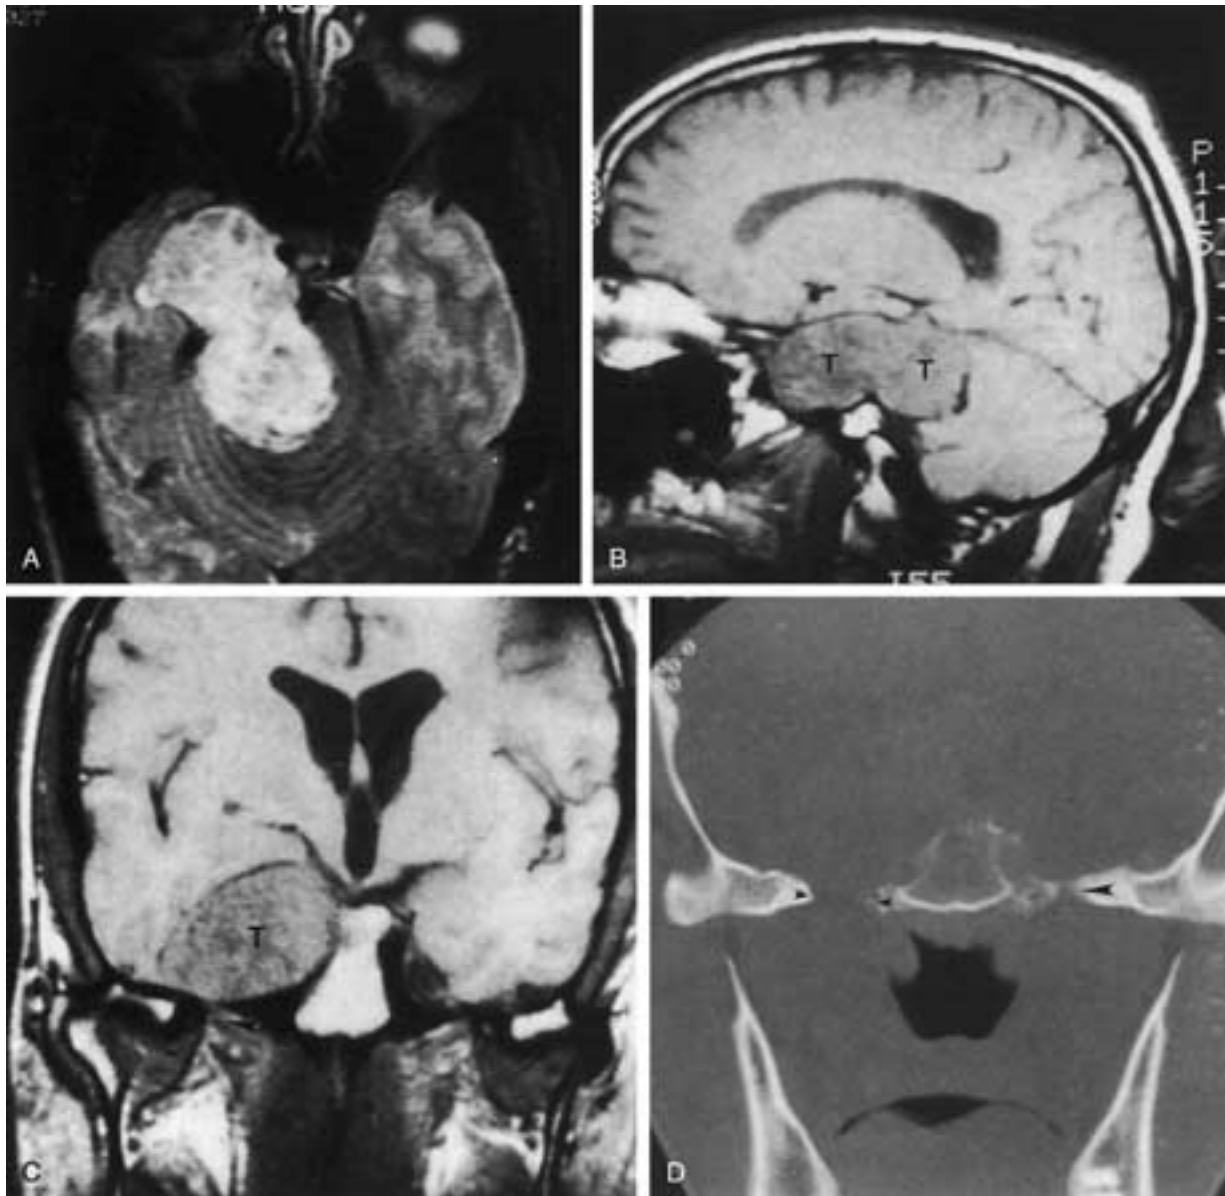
Nerve sheath tumor of the trigeminal nerve (schwannoma). The tumor (*T*) has both a middle cranial fossa and a posterior fossa component. Note that the carotid artery is pushed medially. A, The T2-weighted image shows relatively high signal but areas of intermediate signal as well. B, Sagittal image shows the dumbbell configuration of the tumor, with components both above and below the tentorium. The constriction is at the position of the tentorium. C, Coronal image shows the tumor expanding the region of the cavernous sinus and obscuring Meckel's cave. A small amount of fat (*arrowhead*) is seen just beneath the foramen ovale, indicating that the tumor did not spread by this route. D, Coronal bone algorithm. The foramen ovale between the small black arrowheads is enlarged even though the tumor did not extend through this foramen. Compare with the foramen ovale opposite (*large black arrowhead*).
